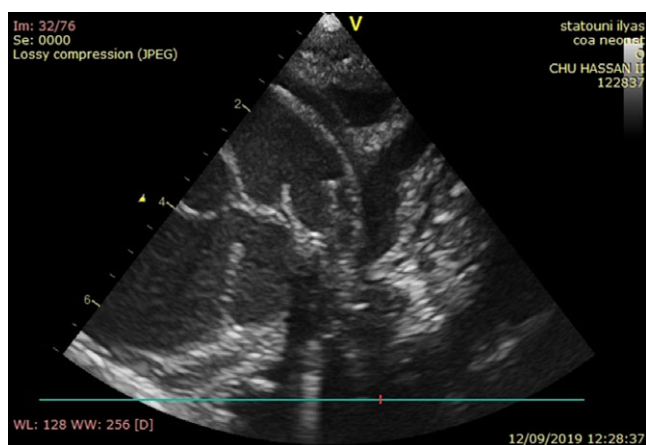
Echocardiography before dilatation.
